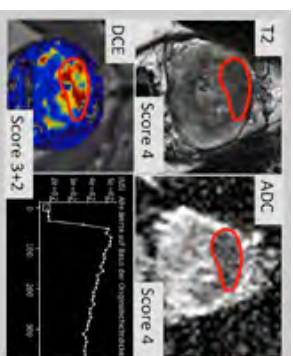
70-year-old patient. After two negative TRUS-biopsies, PSA-levels rose to 6,5 µg/L. Multiparametric MRI was performed. A PI-RADS-Sum of 13 was determined, giving an overall PI-RADS of 5, most probably malignant. Fusion-guided biopsy revealed a Gleason 4+5=9 tumour in 5/5 biopsy cores.
